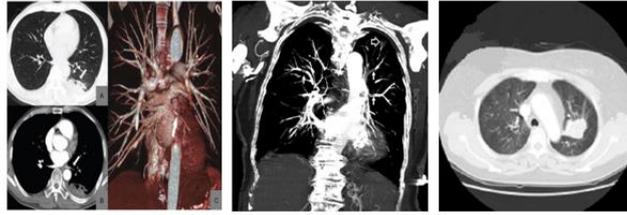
Multislice CT Image of Chest (left), Spiral CT Image of Chest (middle), Conventional CT Image of Chest (right)[16]
